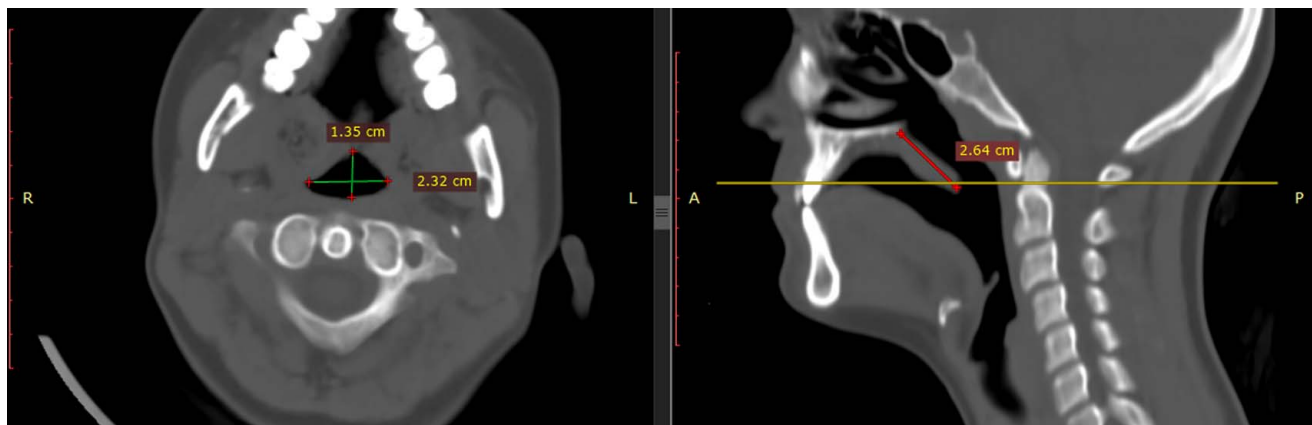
Radiographic measurement of the velopharyngeal port at the level of the incisive foramen that demonstrates the anterioposterior and mediolateral distances before surgery.
